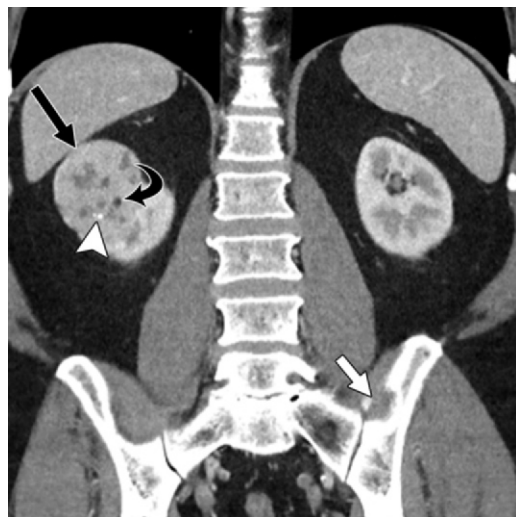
RCC in a 56-year-old man. Coronal contrast-enhanced CT image shows an enhancing right renal mass (straight black arrow). The mass has soft-tissue attenuation, with small foci of calcifications (arrowhead) and fat attenuation (curved black arrow). A metastatic lytic lesion of the left iliac bone (white arrow) is also seen.
